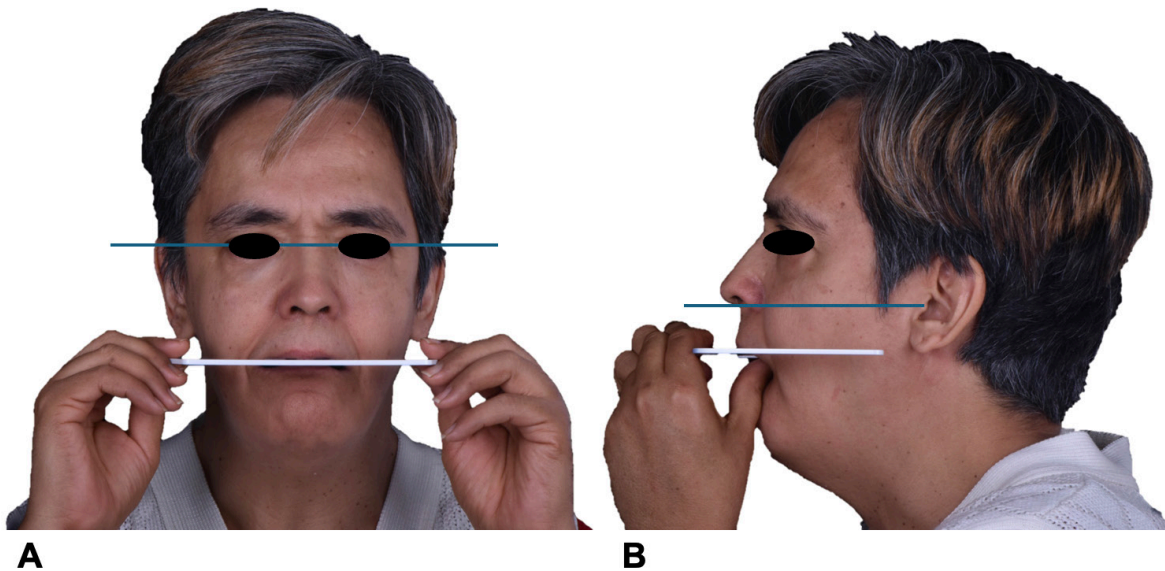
Initial patient status. A. Frontal extraoral photography. B. Left lateral extraoral photography. C. Maxillary occlusal intraoral photography. D. Mandibular occlusal intraoral photography. E. Initial orthopantomographic radiograph.
